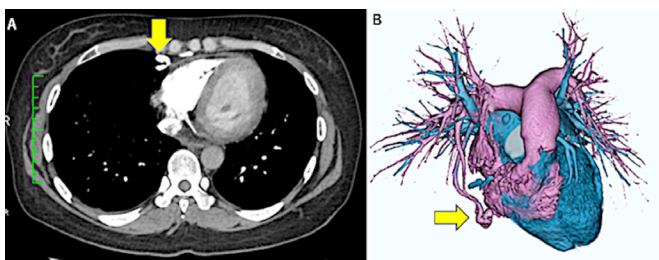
The right pulmonary arteriovenous malformation (PAVM) in enhanced CT. (A) Contrast CT of axial view and (B) 3D reconstruction revealed the right PAVM.
